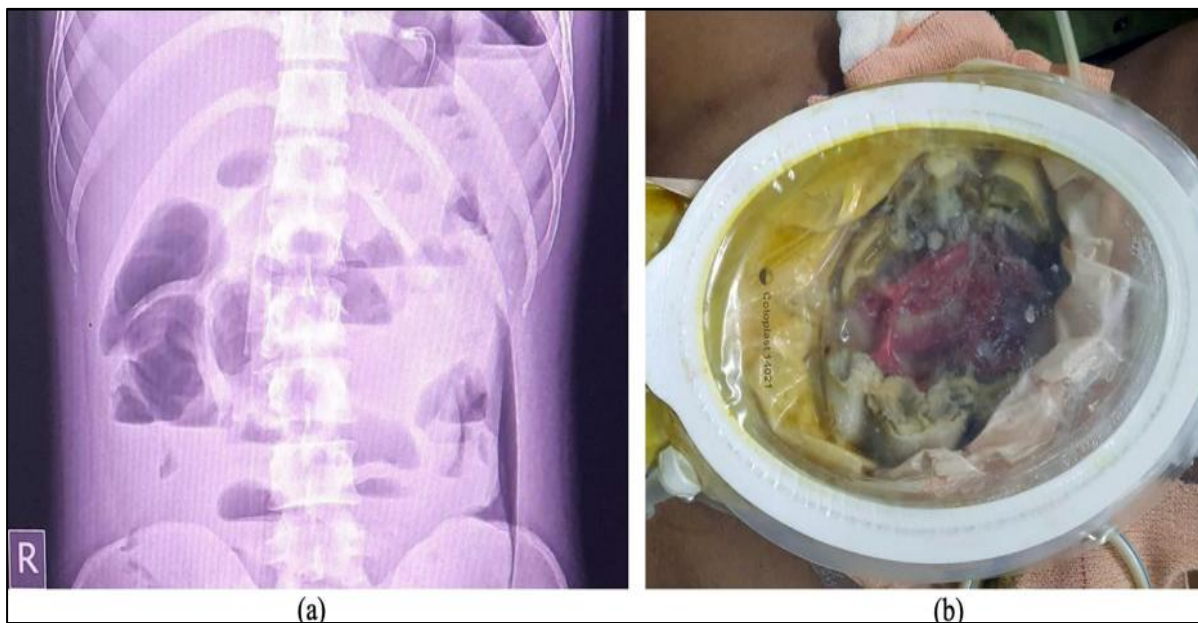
Panel (a) Shows Erect X-Ray Abdomen of Patient 4 Showing Free Air in the Abdomen, Panel (b) Shows Patient 5 Post-Dehiscence of Fascial Sheath with Healthy Granulation Tissue
